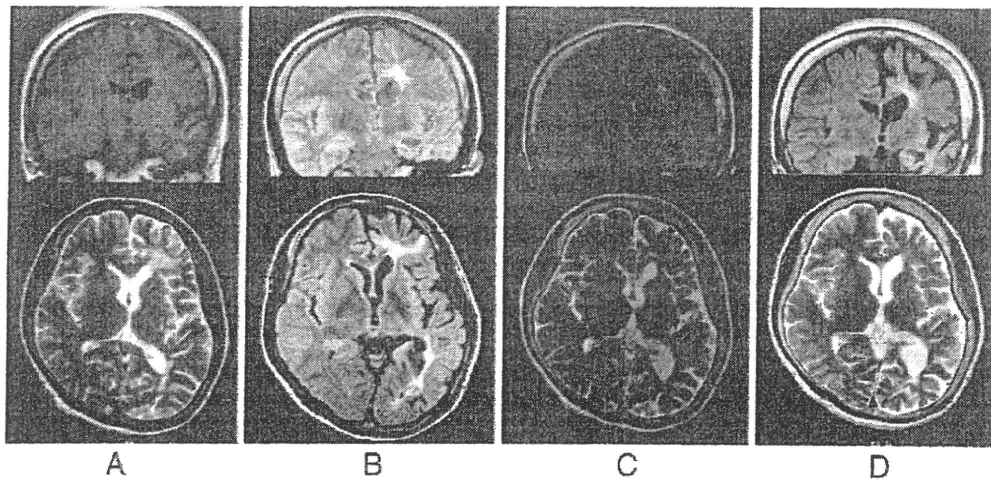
Serial MR images of the patient. Obtained at ages 33 (A), 35 (B), 41 (C) and 48 (D). A: Lower: T2-weighted MR image showing high signal intensity in the white matter and brain atrophy confined to the left hemisphere. Degree of brain hemiatrophy determined as the hemispheric ratio (HR) = 0.91. Upper: Coronal T1-weighted MRI with gadolinium DTPA showing enhanced lesions in the cortex and subcortical white matter of the left temporal lobe. B: MR image showing progressive atrophy of the left hemisphere with a FLAIR-high signal white matter lesion adjacent to the anterior and posterior horns of the left lateral ventricle. HR = 0.86. C: High signal intensity on the T2-weighted image is less marked, but hemispheric atrophy has progressed slightly since age 35. HR = 0.78. D: Cerebral atrophy is still confined to the left hemisphere, HR = 0.79, the same value as at age 41.
